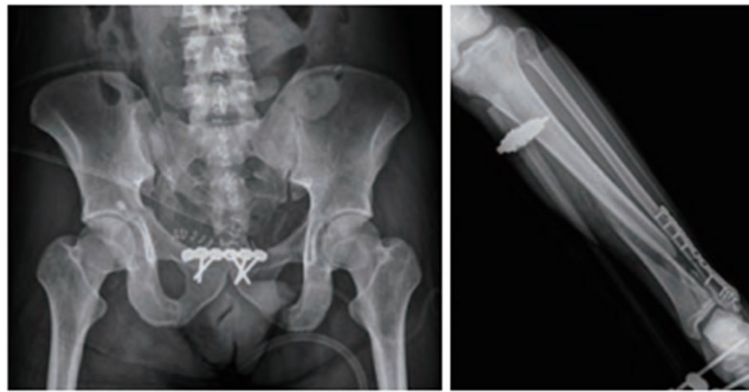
Postoperative anteroposterior radiograph of the pelvis and right leg following definitive surgical stabilization. Internal fixation successfully restored the integrity of the anterior pelvic ring after physiologic stabilization and completion of the damage control phase. Concomitant fixation of the associated tibial fracture was performed during the same reconstructive stage, reflecting the multidisciplinary and staged approach to complex musculoskeletal trauma.
